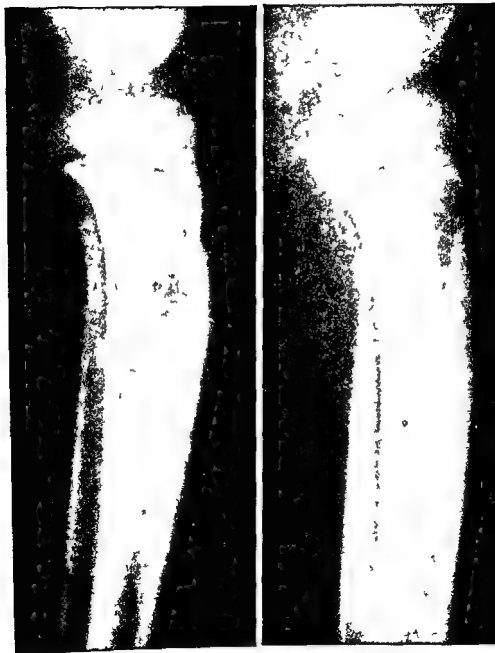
Osteomyelitis of the tibia of two years duration treated with surgery and kana mycin injections (90 days) *Left* Roentgenogram of tibia before treatment *Right* Roentgenogram of tibia after treatment was completed
